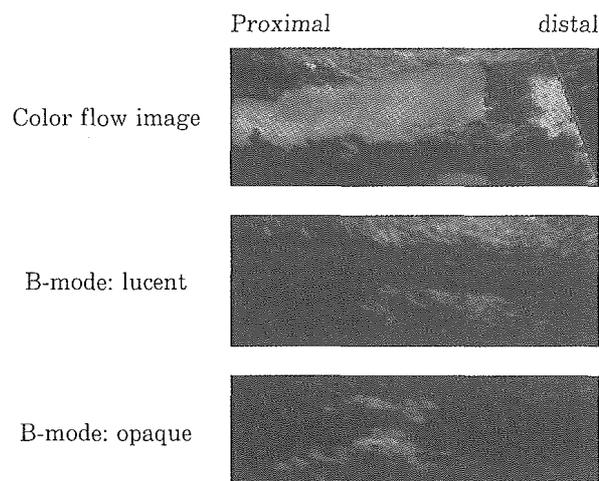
Transoral carotid ultrasonography (TOCU) findings of the distal portion of extracranial internal carotid artery (ICA). Upper; B-mode with color flow image of normal ICA. Middle; B-mode image indicating lucent area inside the ICA. Lower; B-mode image showing partial opaque area inside the ICA.
